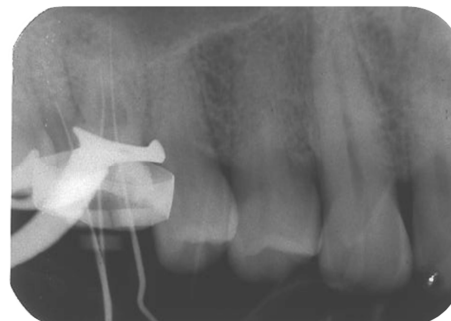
Working lengths radiograph.
